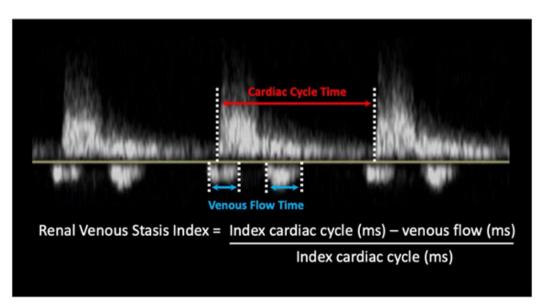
Renal venous stasis index for intrarenal veins Doppler.
